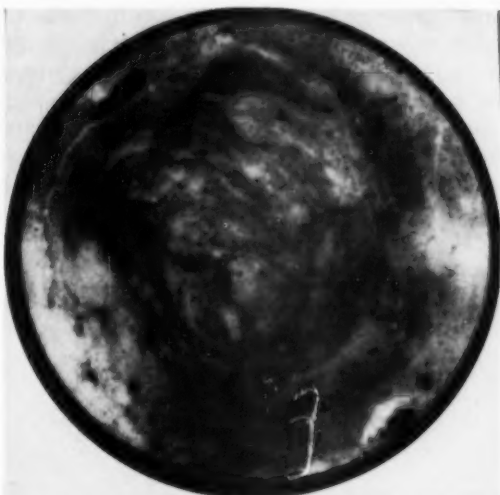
Roentgenogram of mucus mixed with a barium suspension. Note the mottled appearance, as the mucus does not mix homogeneously with the contrast substance.
